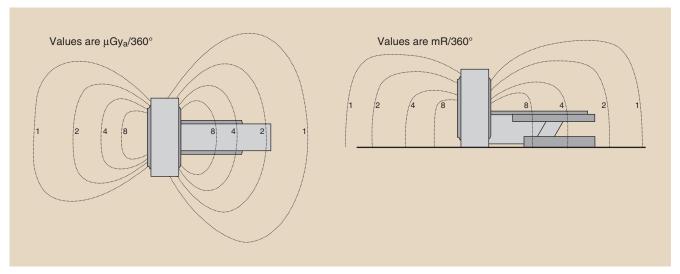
Isoexposure profiles (in mR/360 degrees) in horizontal and vertical planes for multislice spiral computed tomography.
